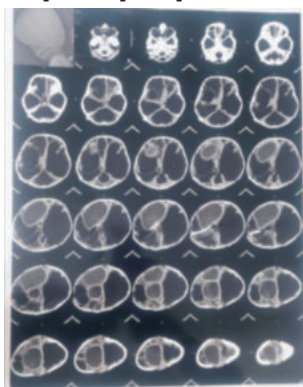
CT Brain showing gross dilatation of both the third
